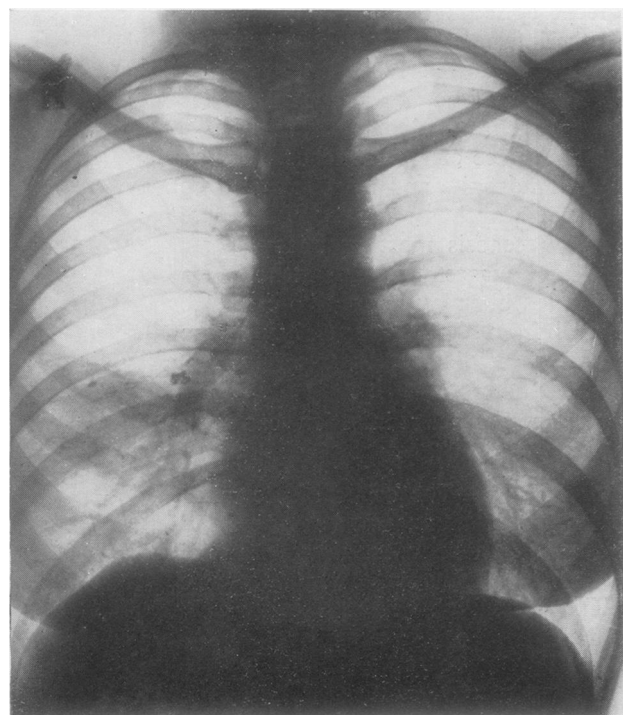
Plain radiograph showing vague "clouding" of lateral part of middle lobe. A calcified primary focus can be seen lying in this area in relation to the fourth rib in front. Calcified glands can be seen at the root.
